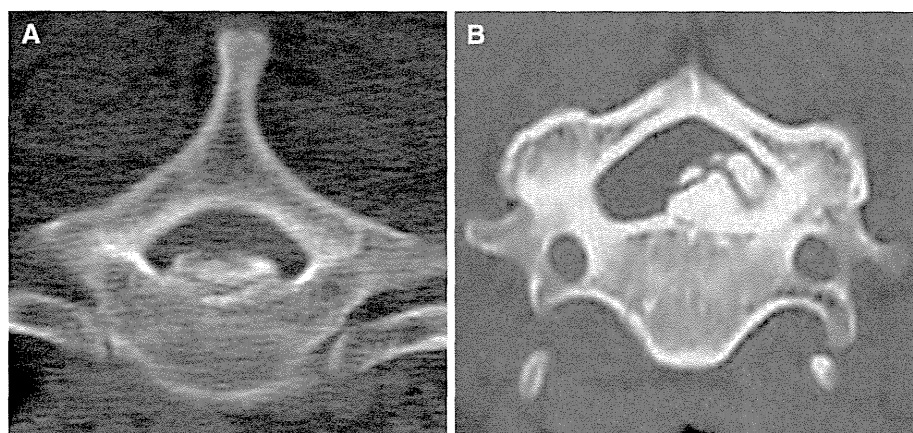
OPLL pattern on CT examination. a central type, b lateral deviated type (reprinted with permission from Matsunaga et al. [39])
